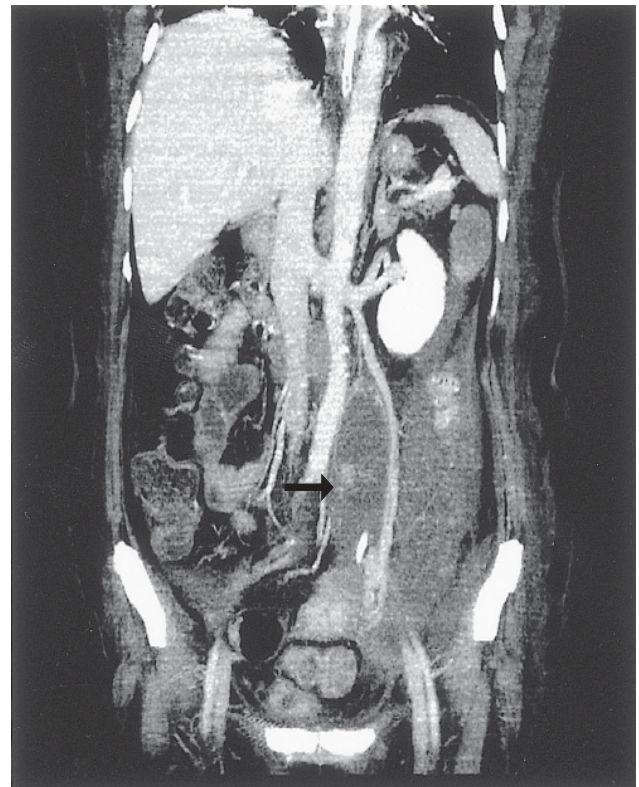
Abdominal computed tomography after reconstruction. A cystic paraganglioma in the left anterior pararenal space with focal contrast extravasation at the left L5–S1 level and a hematoma below the left L4–5 level are present. The arrow indicates the region of the ruptured cystic paraganglioma with contrast extravasation.
